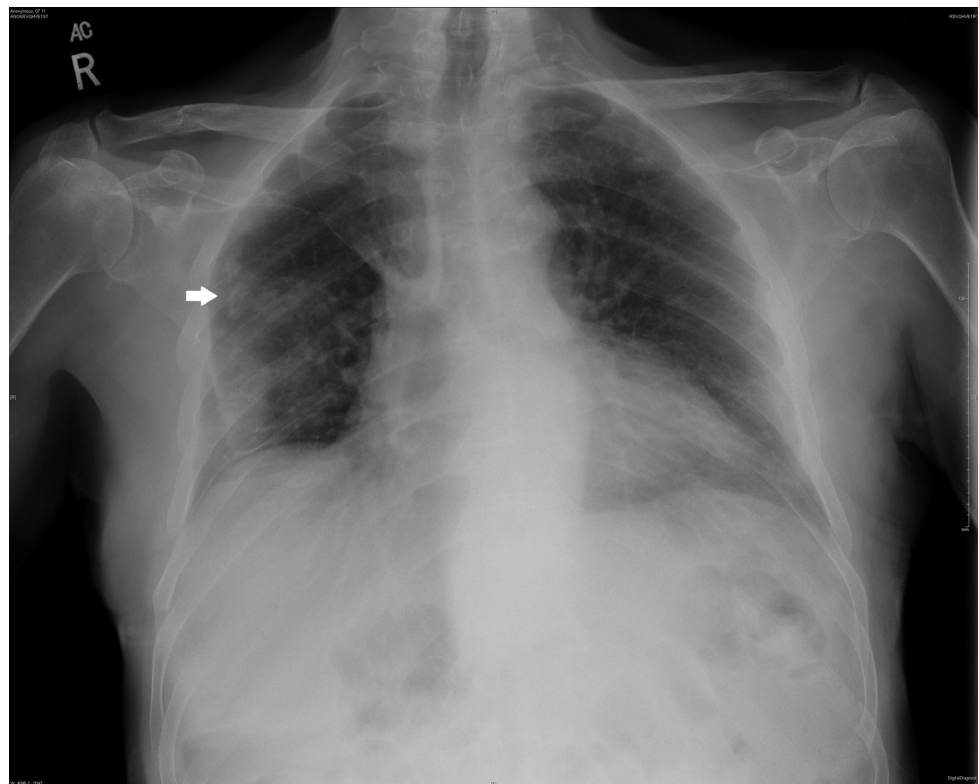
Chest radiograph showing right middle zone patchy lung infiltrates.
